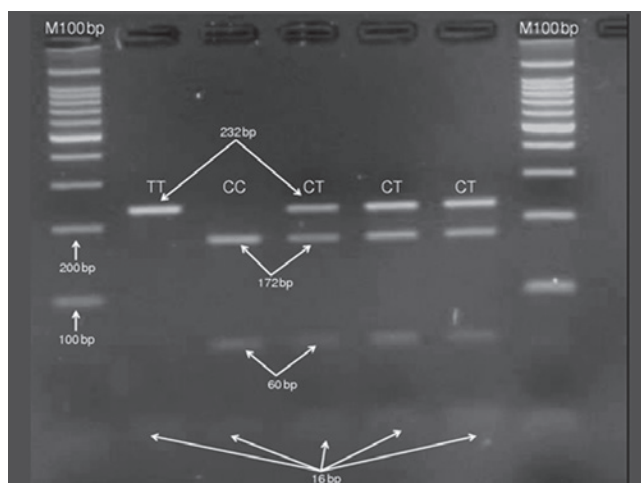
Detection of the length of polymorphisms by PCR followed by agarose gel electrophoresis. Wild-type CC genotype showing three fragments (172, 60 and 16 bp); homozygous mutant TT genotype showing two fragments (232 and 16 bp) and heterozygous CT genotype showing four fragments (232, 172, 60 and 16 bp).
